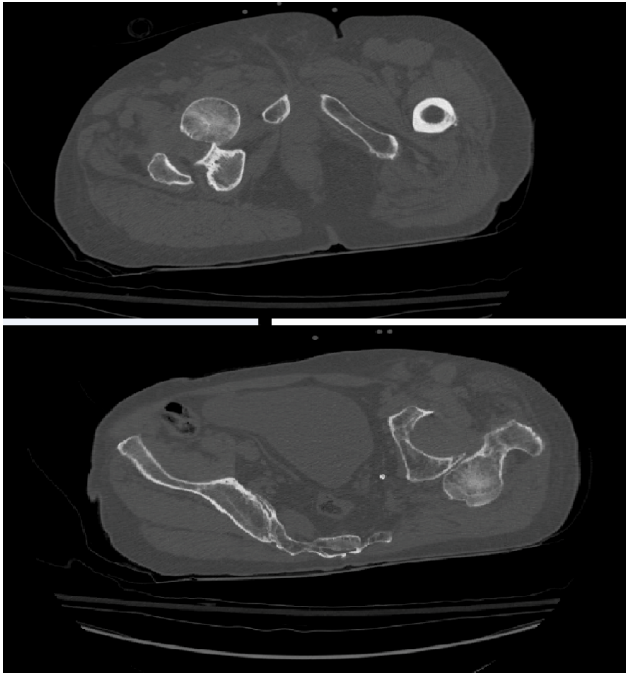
CT appearance of bilateral divergent dislocation of the hip (posterior dislocation of the left hip, and anterior on the right).
